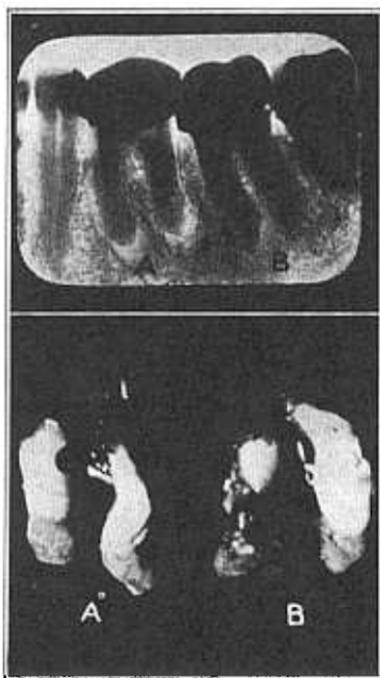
First and second lower molars shown in *A* and *B*, above, and their roots, with granulomas, after extraction, as shown in *A* and *B*, below. The granulomas are larger on the second molar than on the first molar, though their presence is not revealed roentgenographically.
